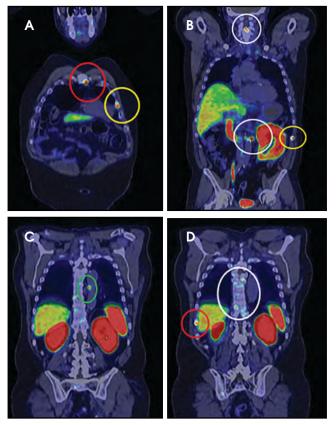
Ga68 PSMA PET/CT scan revealed PSMAavid metastatic lesions throughout the axial and appendicular skeleton, including the sternum (A), ribs (A, B, and D), and spine (B and D). Additionally, there was a solitary aortoesophageal PSMA avid lymph node (C).
